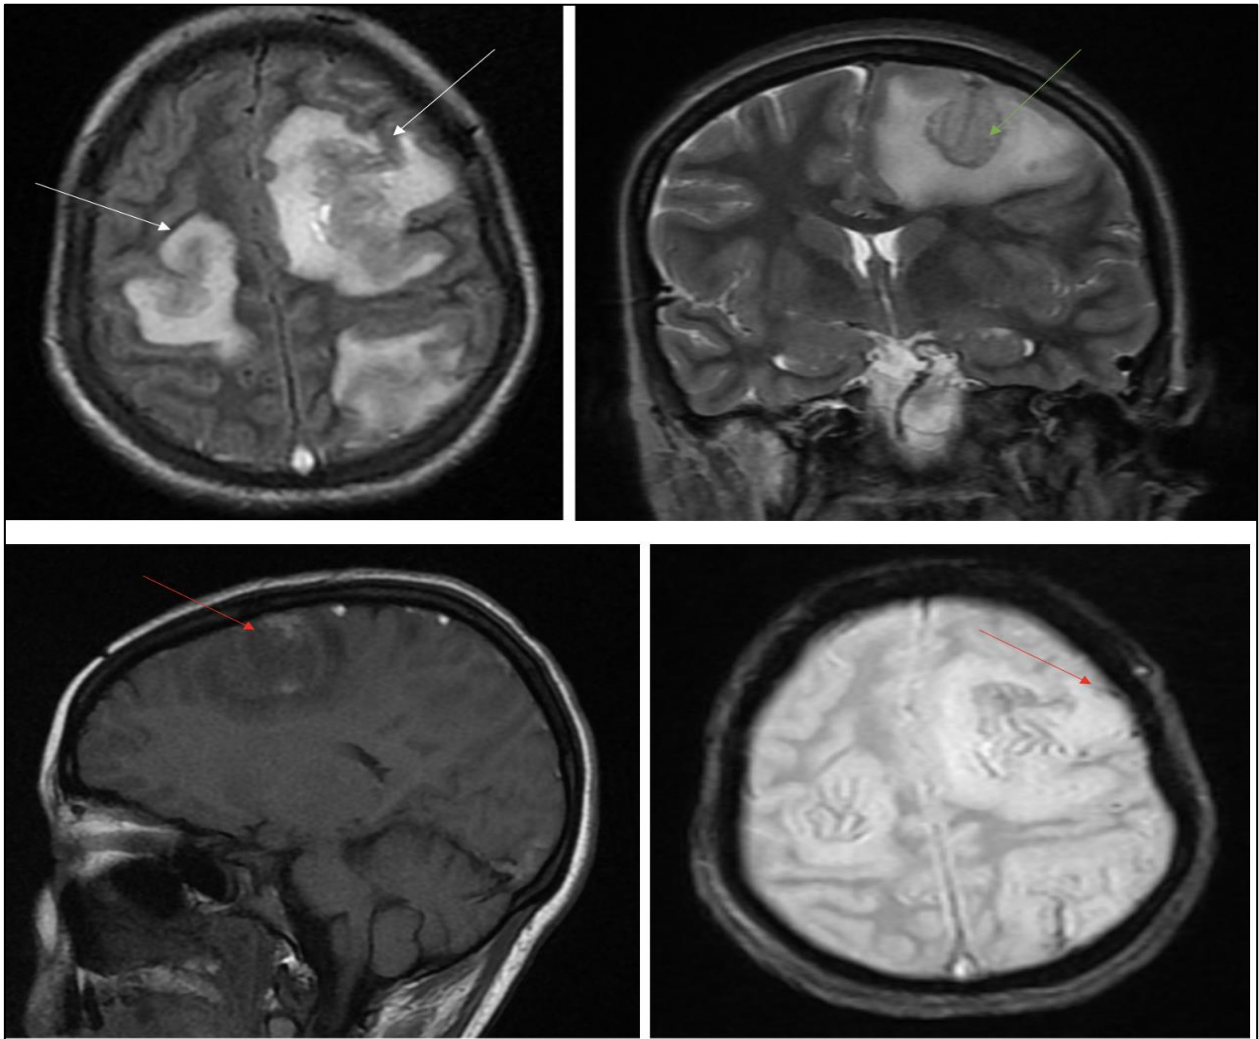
FLAIR, T2, T1 and T2* sequences of a cerebral MRI: Cortico-subcortical folds mainly subcortical at the left fronto-parietal and right frontal level, without arterial systematization, described in FLAIR hypersignal (white arrows) and T2 hypersignal (green arrow), in T1 hyposignal, containing within them areas in T1 hypersignal and T2* hypersignal, in relation to hemorrhagic reorganizations (red arrows)
